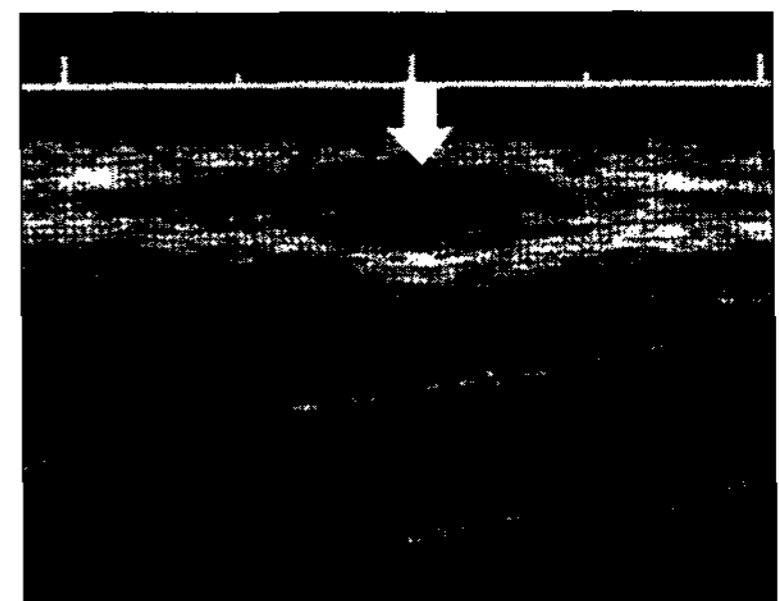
Ultrasound image of the anterior shin revealing hypoechoic mass (arrow) with well-defined borders. The mass size is 0.8 × 1.2cm.
